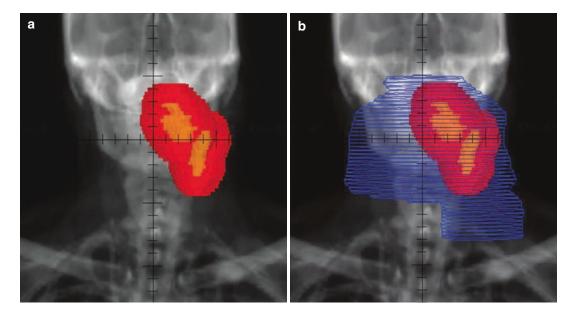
Radiation treatment planning digitally reconstructed radiograph of a patient with oropharynx cancer and left level II adenopathy. (a) Represents a good response to induction chemo and was treated with RVAD, radiation delivered to a single volume to cover gross
